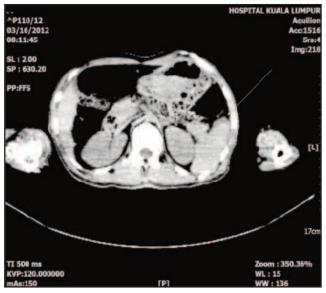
Axial view of plain post mortem CT scan of a patient showing hypodense perisplenic haematomas (thin arrow). CT diagnosis of liver and splenic injuries was made. Subsequent internal conventional autopsy showed the liver and spleen were normal, a false positive finding.
